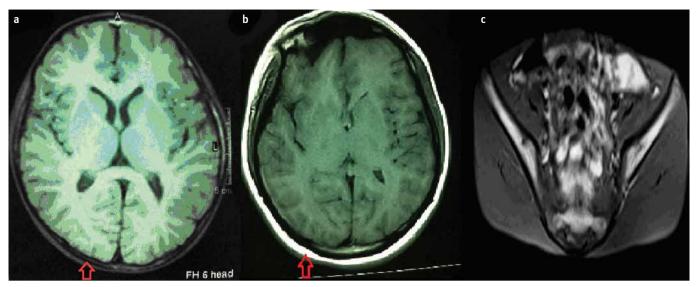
a, b. Loss of subcutaneous adipose tissue is seen in patient's cranial MRI (see arrow) (a), a normal cranial MRI with subcutaneous adipose tissue, c. loss of subcutaneous adipose tissue in patient's pelvic region in pelvic MRI (b).
